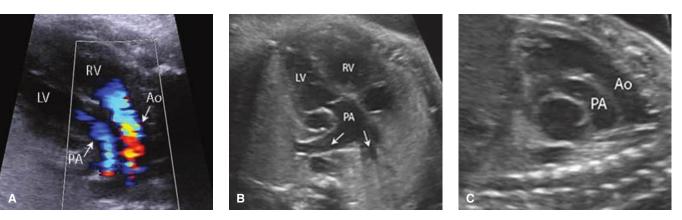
D-transposition of the great arteries. A. Transverse image with color Doppler depicting the outflow tracts arising in parallel. B. View of the left ventricle giving rise to the pulmonary artery, which subsequently branches (*arrows*). C. Sagittal image of the aorta arising anteriorly from the right ventricle and parallel to the pulmonary artery, which arises posteriorly. Ao = aorta; LV = left ventricle; PA = pulmonary artery; RV = right ventricle.
